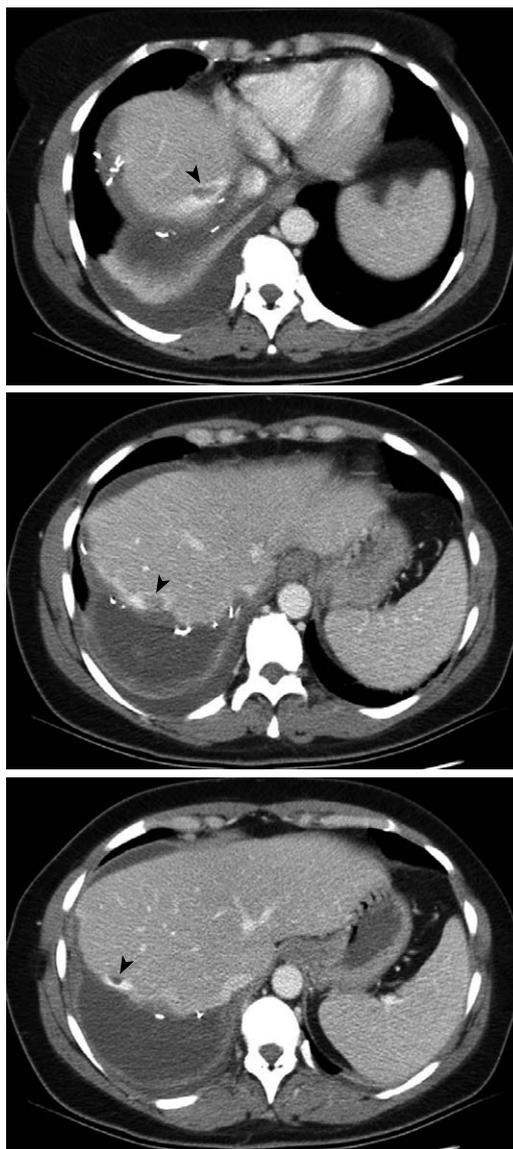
Postoperative computed tomography scan (day 4) in case 1. Defects are present in the middle hepatic vein close to the transection plan (arrowheads).
